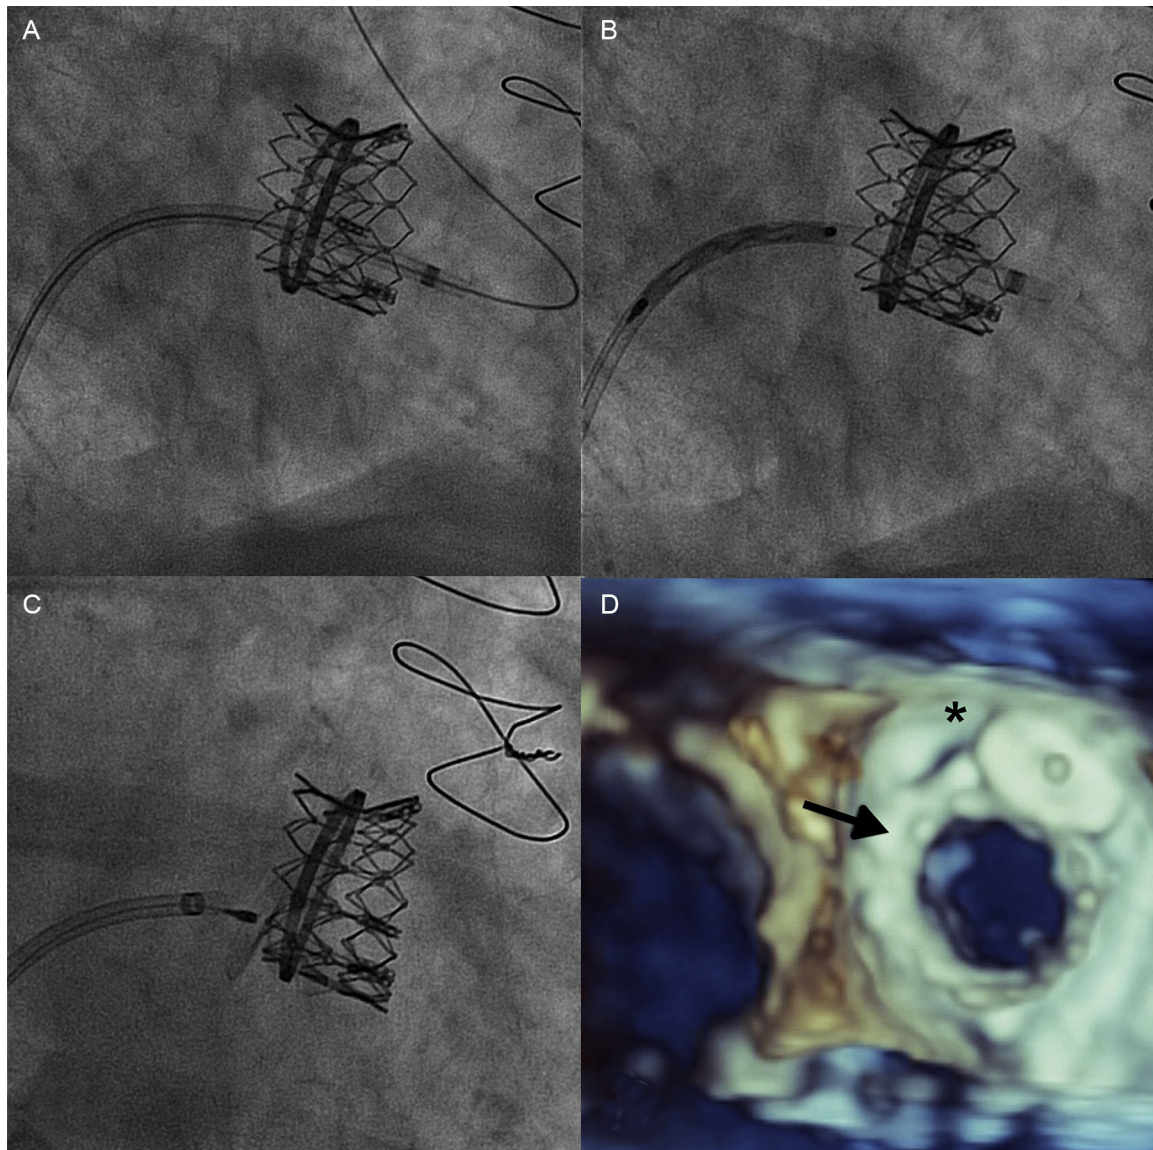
Para-ring leak closure. A: Sheath advance through the leak, into the left ventricle. B: Advance of the 14/5 Amplatzer vascular plug III device. C: Vascular plug implant. D: Final echocardiographic result (SAPIEN XT valve, arrow. Vascular plug, asterisk).
